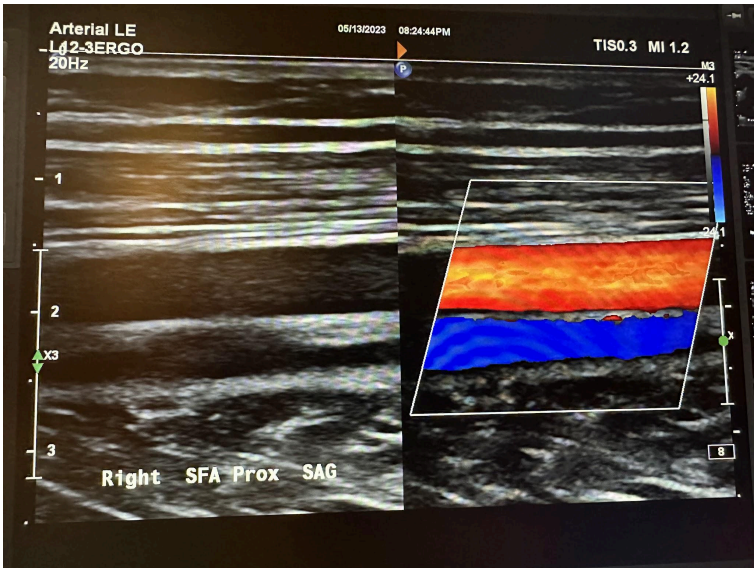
Side-by-side sagittal images of the right proximal superficial femoral artery without color Doppler and with color Doppler.
